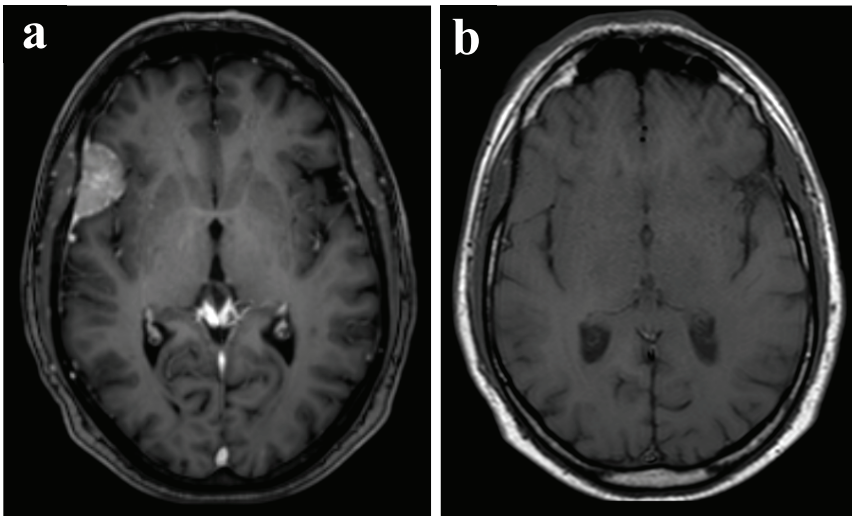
Meningioma in the right frontal region. 4a: T1-weighted sequence with contrast enhancement. 4b: T1-weighted sequence without contrast enhancement.
